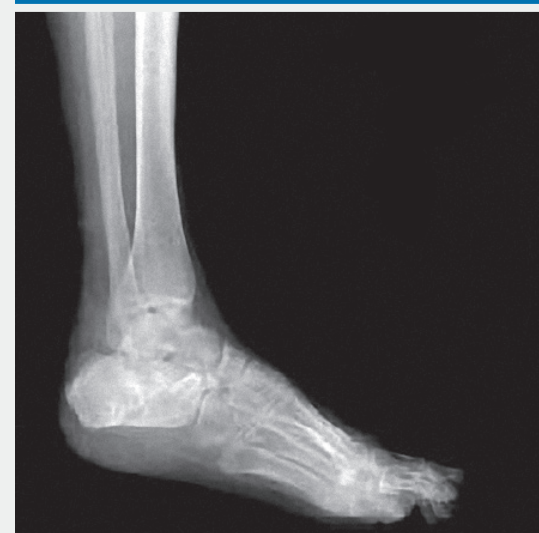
Final post-operative radiograph.
